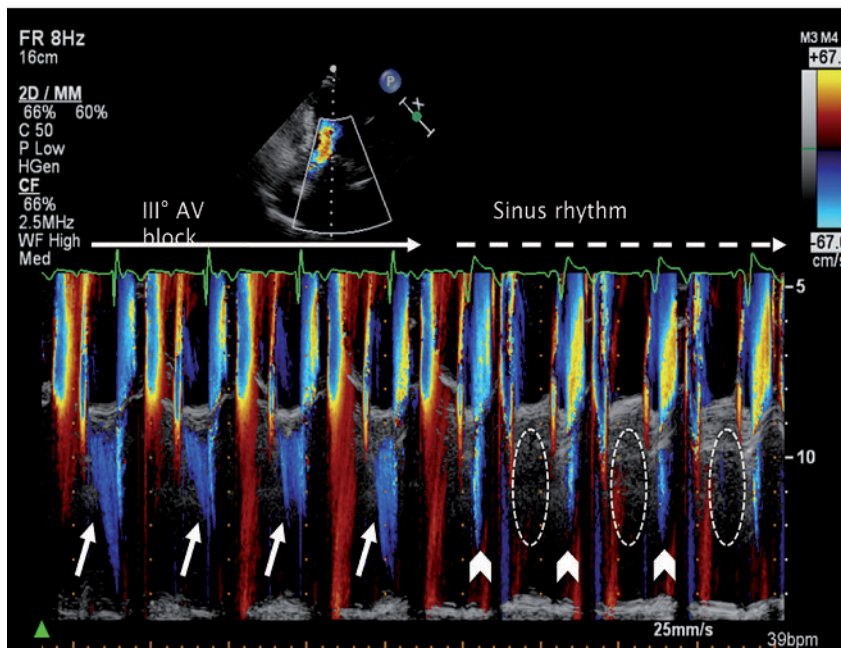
Colour-Doppler M-mode through the mitral valve. During complete atrioventricular (AV) block, diastolic mitral regurgitation is present (long arrows). After conversion into sinus rhythm, minimal systolic MR is noted (arrow heads), while diastolic MR is absent (dashed circles).
